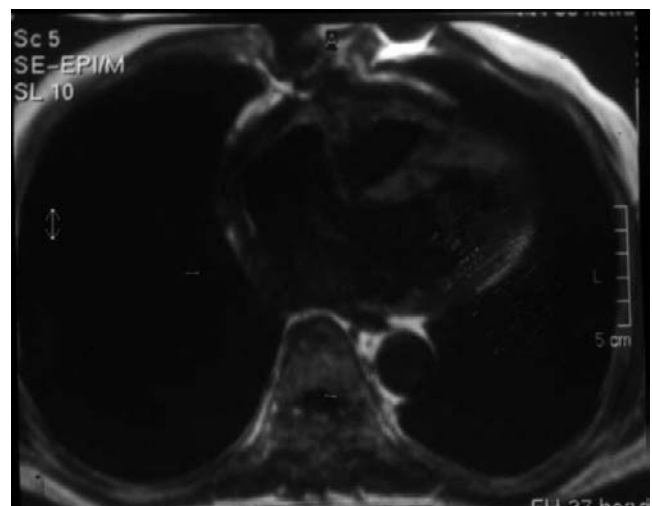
MRI obtained after therapy. No pleural effusion is seen, although there is residual thickening of the pericardial anterior wall.
